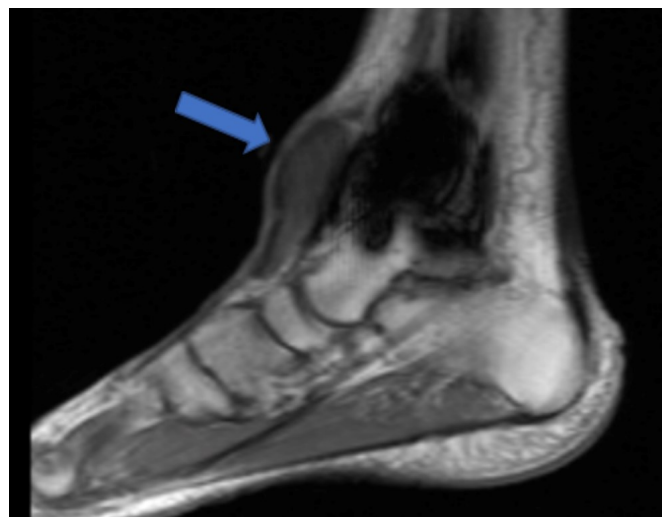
MRI of Left Lower Extremity Sagittal T1 - hypointense signal (arrow) within the tumor with ankle artifact secondary to previous ORIF seen.
